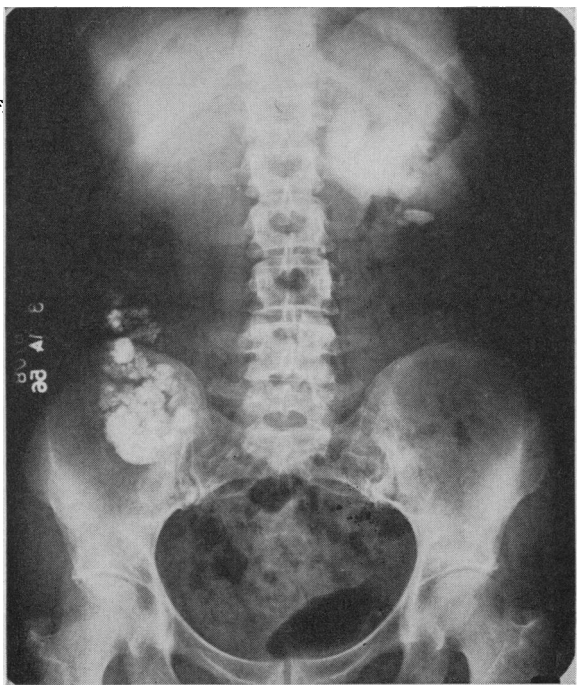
(Case 3).—Kidney-ureter-bladder x-ray film. This demonstrates large and smaller calculi filling the left renal pelvis, and multiple small calculi in a decidedly hydronephrotic right kidney.
